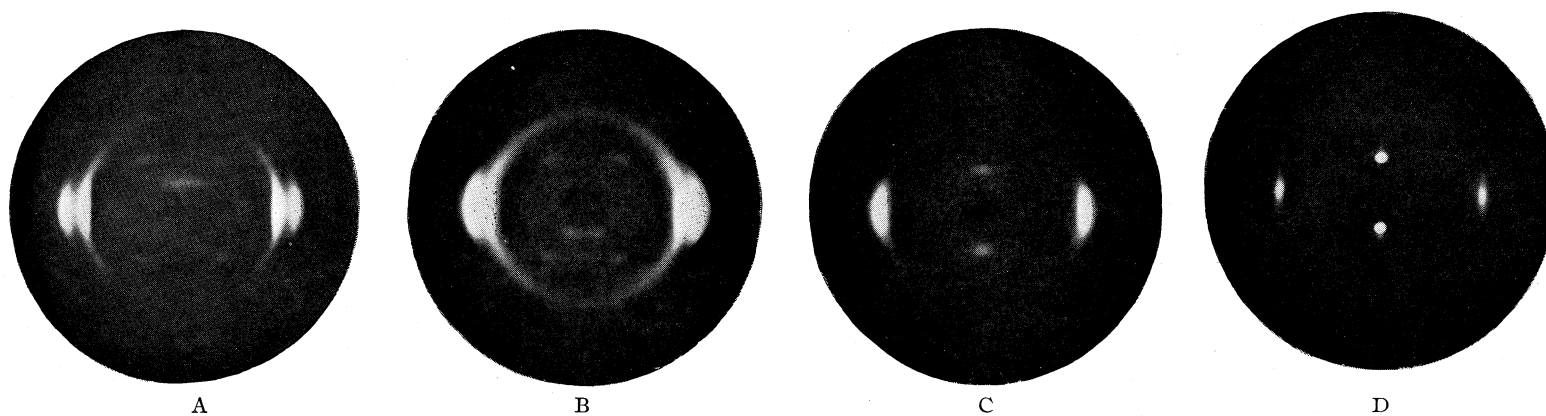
X-Ray patterns of oriented polyamides and copolyamides of the 6-6:9-9 series: A, 100% 6-6; B, 80% 6-6 and 20% 9-9; C, 50% 6-6 and 50% 9-9; D, 100% 9-9.
